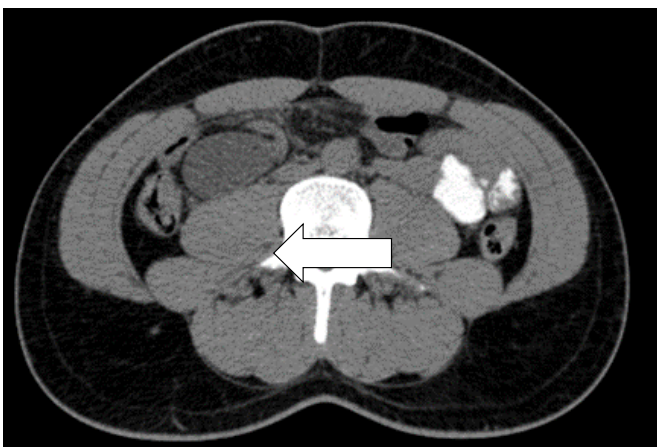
CT scan abdomen. Arrow indicates angulation of the small bowel.
